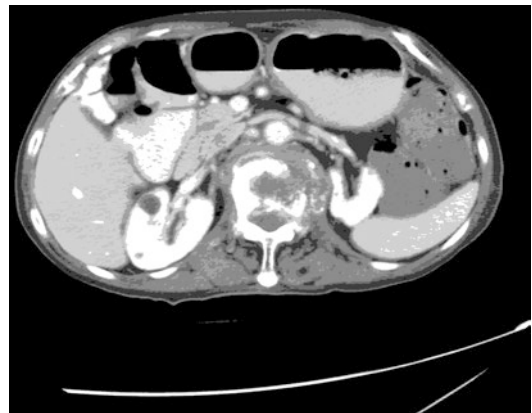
CT scan of the abdomen and the level of the T12 demonstrate a destructive lesion of the body of T12 on the left side extending into the left parapelvic region with some calcification and enhancement peripherally
